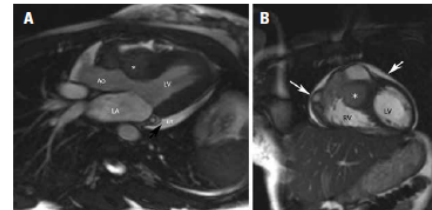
Cardiac MRI showing the mass within the interventricular septum (asterisk) and circumferential pericardial effusion (arrows) at the T2 weighted long-axis (A), coronal views (B)
